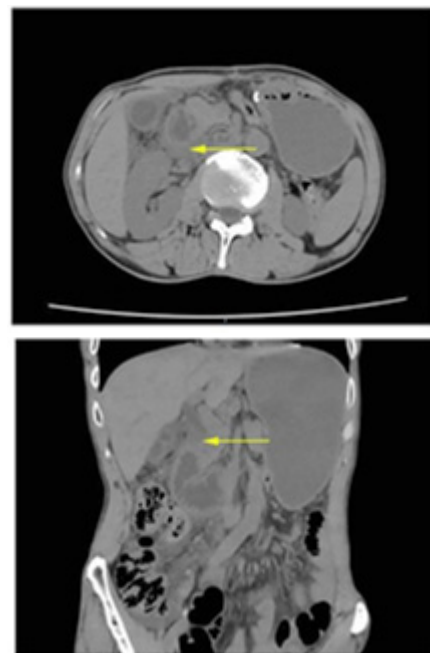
Preoperative abdominal magnetic resonance imaging showed a huge mass in the right upper abdomen, which was closely related to the duodenum and gastric antrum. C,D Preoperative gastroscopy showed protruding lesions in the first part of duodenum and gastric antrum, which was considered as lateral wall compression.
